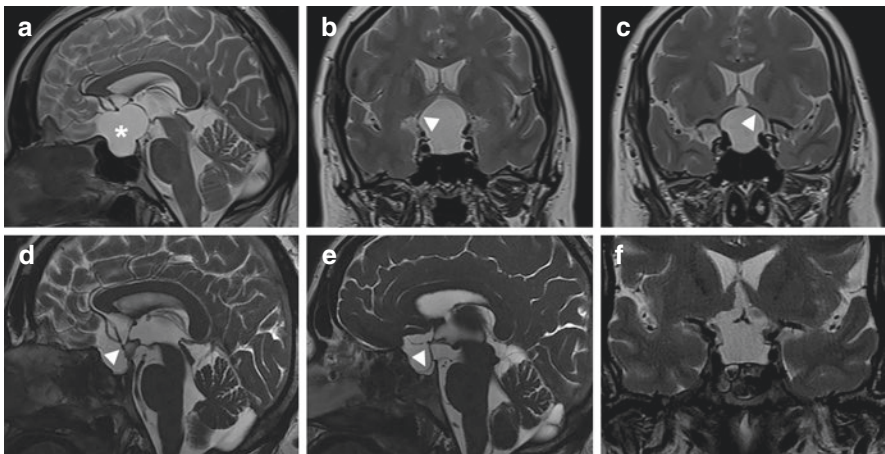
Intrasellar arachnoid cyst. Preoperative T2-weighted MRI (a–c) revealing an intrasellar arachnoid cyst with suprasellar extension. (a) The lesion (asterisk) expands the sella turcica and causes compression of the floor of the third ventricle. (b) Coronal image demonstrating the stretched optic chiasm (arrowhead) on the superior aspect of the cyst wall. (c) Coronal image demonstrating the stretched A1 segment (arrowhead) on the superior aspect of the cyst wall. Postoperative T2-weighted MRI (d–f) revealed a full decompression of the cyst with notable descent of the anterior cerebral complex vessels (d; arrowhead) and superior cyst wall (e; arrowhead and f)
